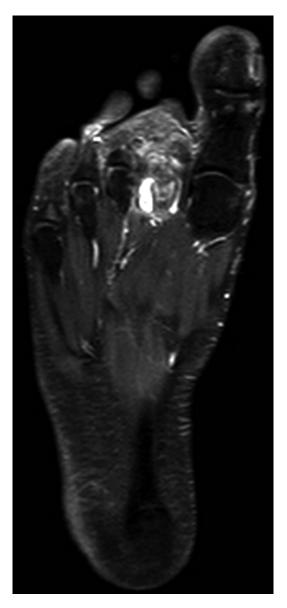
MRI (T1-weighted sequence with fat saturation and intravenous contrast) shows bone marrow and soft-tissue oedema centred on the second metatarsal, which enhance with contrast
